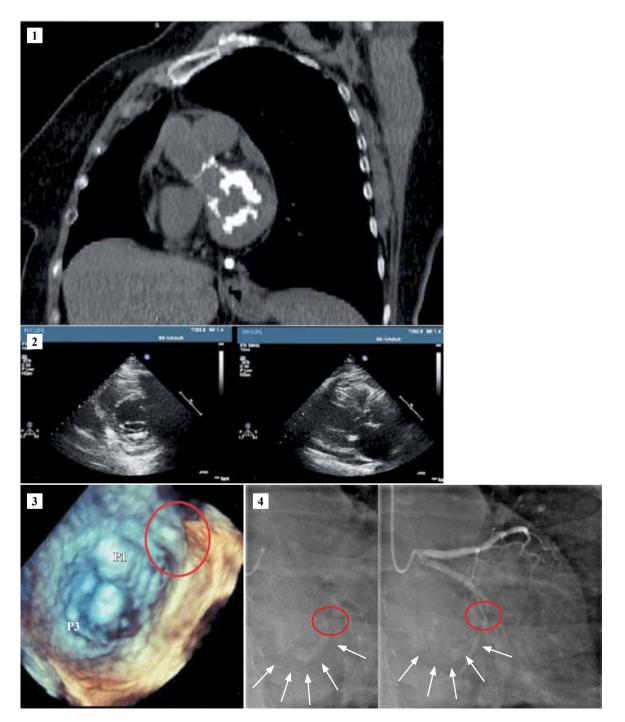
Computed tomography: 1 - Chest MSCT; 2 - echocardiography, longitudinal and cross-sectional parasternal access; 3 - 3D reconstruction of the mitral valve; 4 - coronary angiography (arrows show mitral annulus calcification, the circle indicates the possible location of coronary artery lesion)
